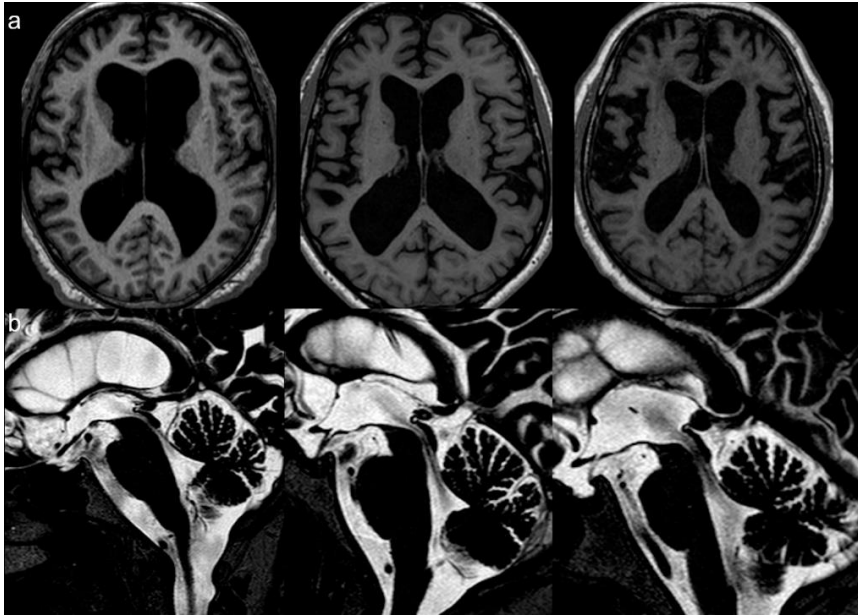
Anterior interhemispheric fissure graded 0 (normal), 1 (slight widening), 2 (marked widening) on T1-weighted axial images (a). Flow void sign in the cerebral aqueduct graded 1, 2, 3 according to the modified Algin scale on T2-weighted sagittal images (b).
